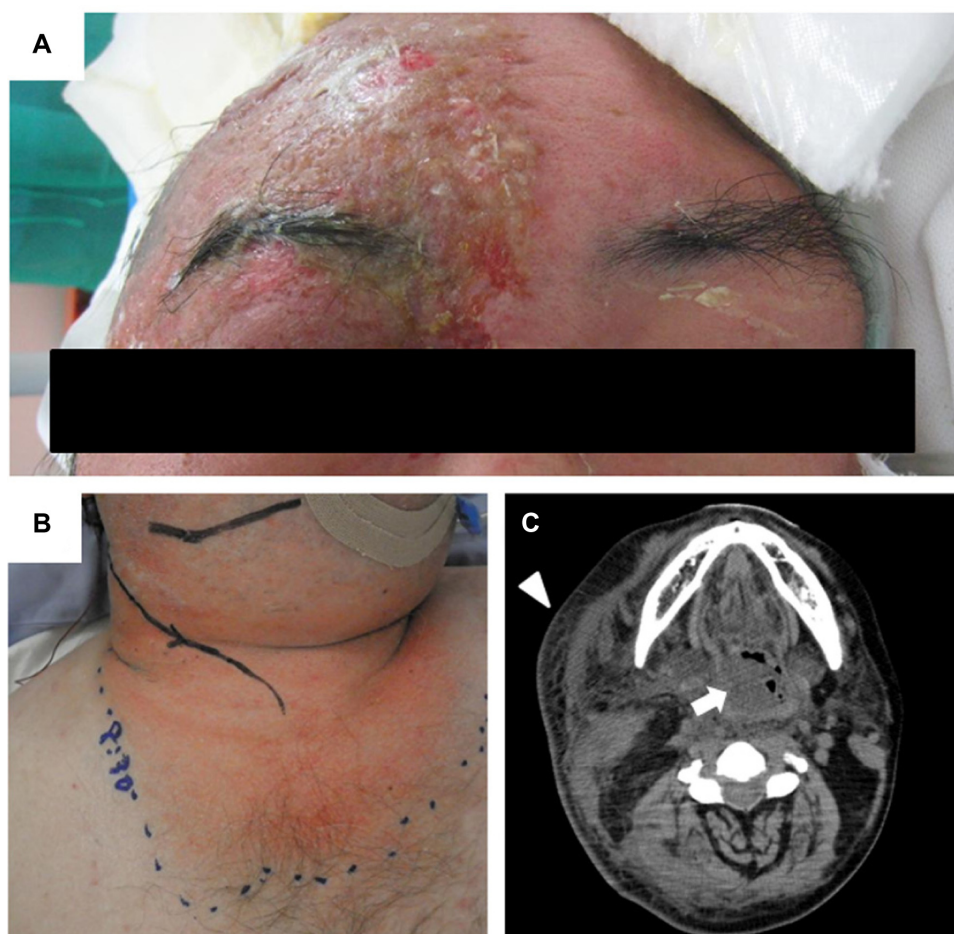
(A) A photo obtained on hospital day 5 showing a tender erythematous, vesicular, crusting lesion on the right periorbital skin. (B) An erythematous patch without a vesicular rash over the perilyngeal skin just after intubation. (C) Axial CT of the neck demonstrating an expansive lesion in the right supraglottic region (arrow). Note that diffuse reticulation of subcutaneous fat was detected in the right cervical territory, suggesting cellulitic inflammation (arrowhead).
